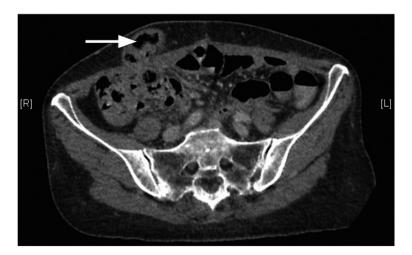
Cross-sectional computed tomography of spontaneously closed loop ileostomy (white arrow).
